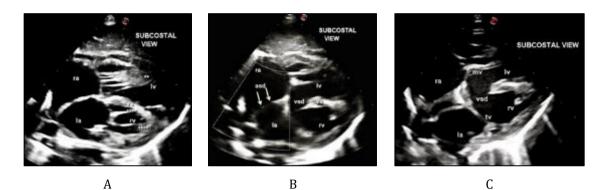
Transthoracic 2D Color Echocardiography. (A) In the subcostal view, the anterior dilated left ventricle is identified by the insertion of chordae of the mitral valve to the free wall of LV (denoted by double asterisk). The left ventricle is lying anterior and to the right of RV (ventricular inversion). The hypoplatic right ventricle is recognized by the insertion of the chordae of tricuspid valve to the ventricular septum and the RV apex (denoted by triple asterisk). (B) In the subcostal view, a moderate size ostium secundum ASD and a large inlet VSD are demonstrated. (C) Subcostal view depicting large inlet VSD, dilated anterior LV, hypoplastic posterior RV
